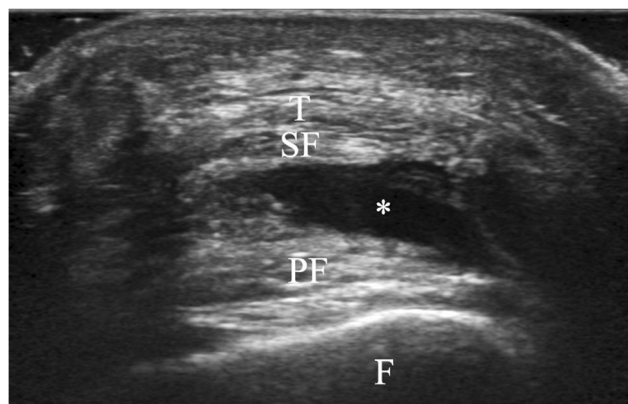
Ultrasound image, transverse view of the suprapatellar pouch (F, femur; T, quadriceps tendons; SF, suprapatellar fat-pad; PF, prefemoral fat-pad; asterisks, suprapatellar pouch)
